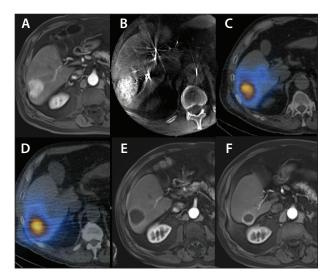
Pretreatment, avid arterial enhancement of 3.9- X 4.2-cm HCC tumor in segment 6/7 (A). CBCT ensured complete coverage of the tumor from the location of the microcatheter where the MAA and future Y-90 was to be administered from (B). Tc99m MAA SPECT/CT confirmed the complete coverage of the targeted tumor within segment 6/7 and absence of extrahepatic activity (C). Y-90 bremsstrahlung SPECT/CT confirmed the complete coverage of the targeted tumor within segment 6/7 and absence of extrahepatic activity (D). Posttreatment MRI arterial phase images at 6 weeks and 6 months, respectively, demonstrated complete response without recurrence of disease (E, F).
